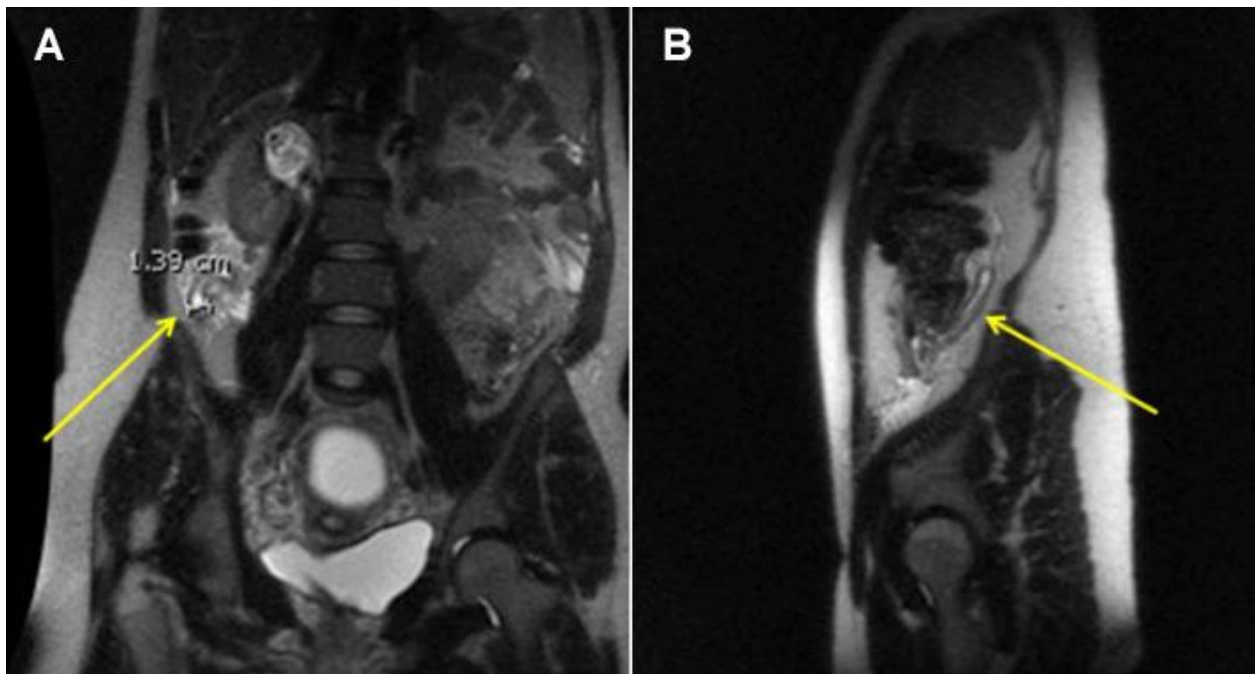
MRI Abdomen - Acute Appendicitis with Appendicolith
